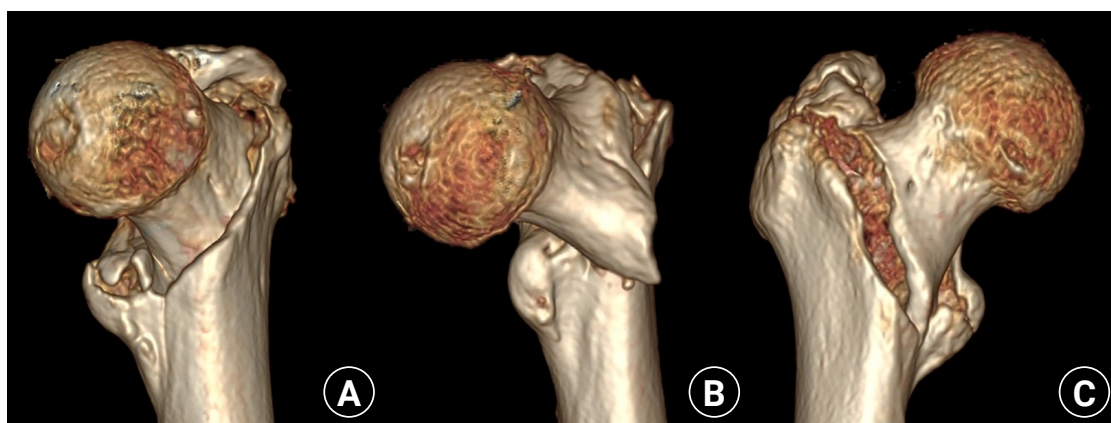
Representative three-dimensional computed tomography images of intertrochanteric fractures: (A) engaged type, (B) completely displaced type, and (C) partially displaced type.
